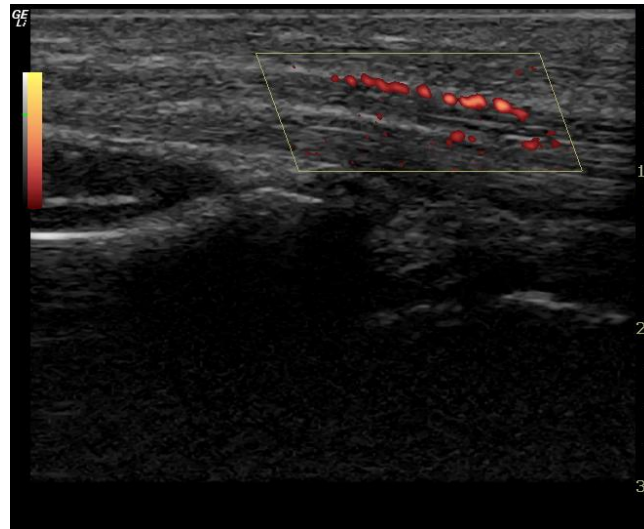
Sagittal sonogram of the median nerve at the distal radius demonstrating the use of power Doppler to detect arteriole blood flow.
